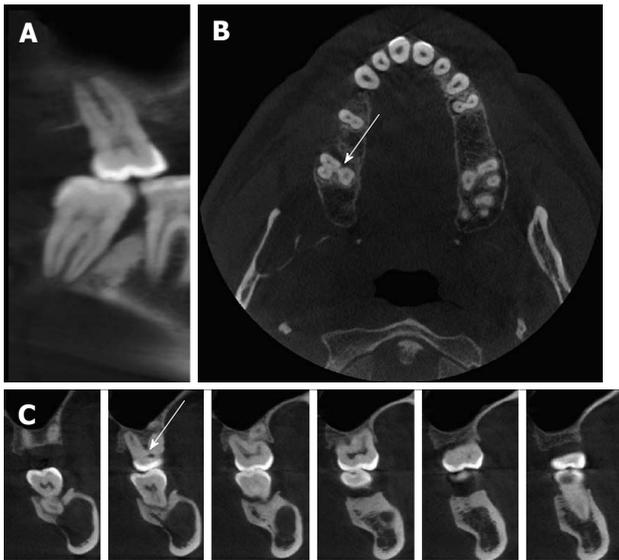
Furcation involvement can not be observed in the panoramic-like section (A) whereas it can be evaluated in the axial (B) and cross-sectional (C) cone beam computed tomography image (arrows).
